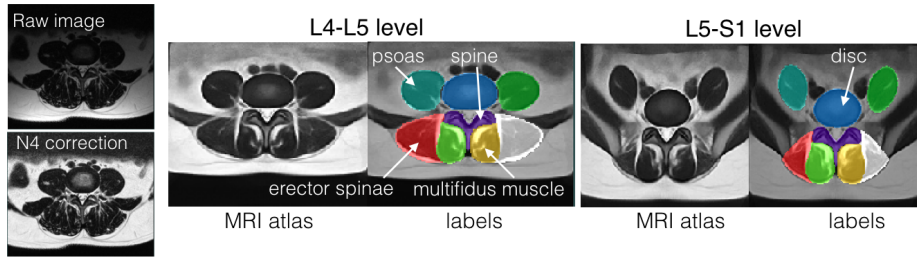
Cross-sectional MRIs of paraspinal muscles at the L4-L5 and L5-S1 levels with different tissue classes using population-averaged MRI atlases.
